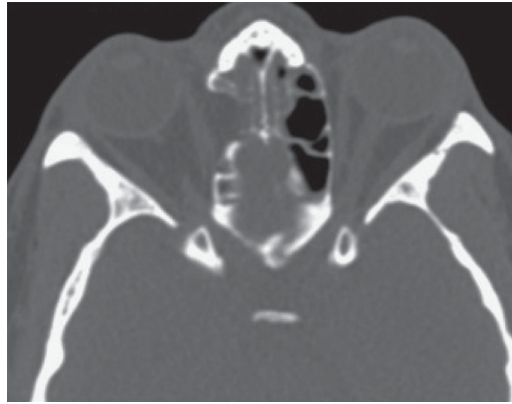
CT scan of the sinuses showing the presence of diffuse mucoperiosteal thickening throughout the paranasal sinuses with abnormal extension into the pterygoid palatine fossa through the sphenopalatine foramen on the right side more than the left.
